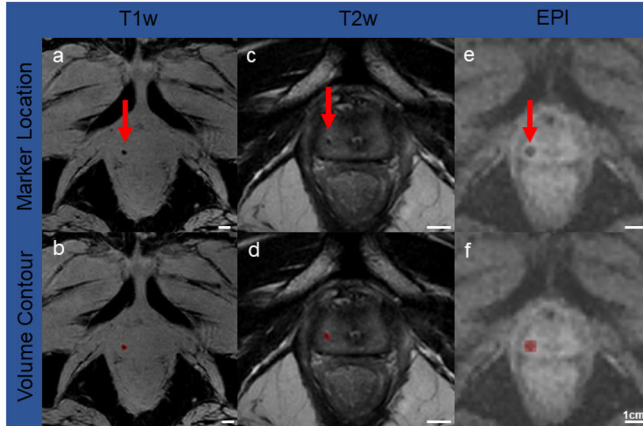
Demonstration of susceptibility artifact segmentation for three different MRI sequences for a gold marker (From original publication I)
